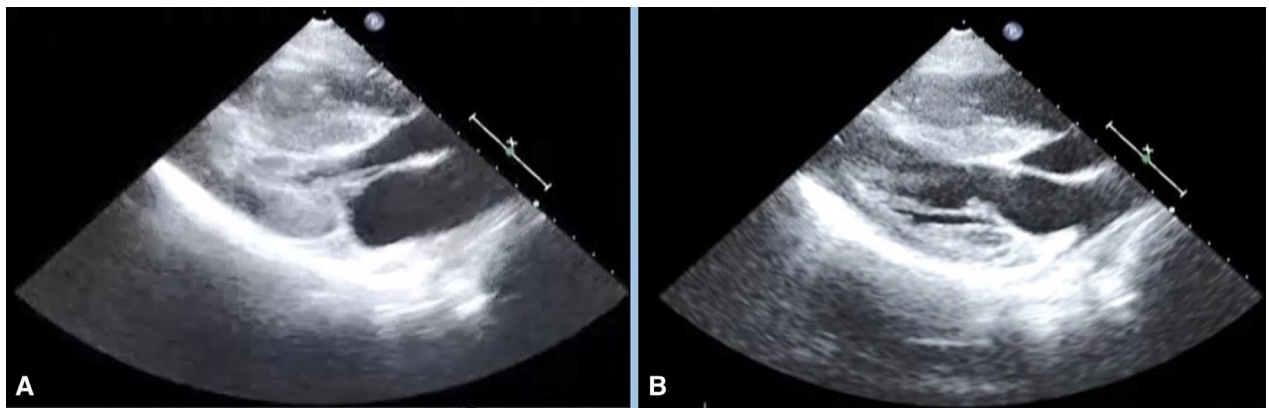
Echocardiography revealed that mean pressure gradient of 40 mm Hg across the left ventricular outflow tract. A, systolic period, B, diastolic period.
